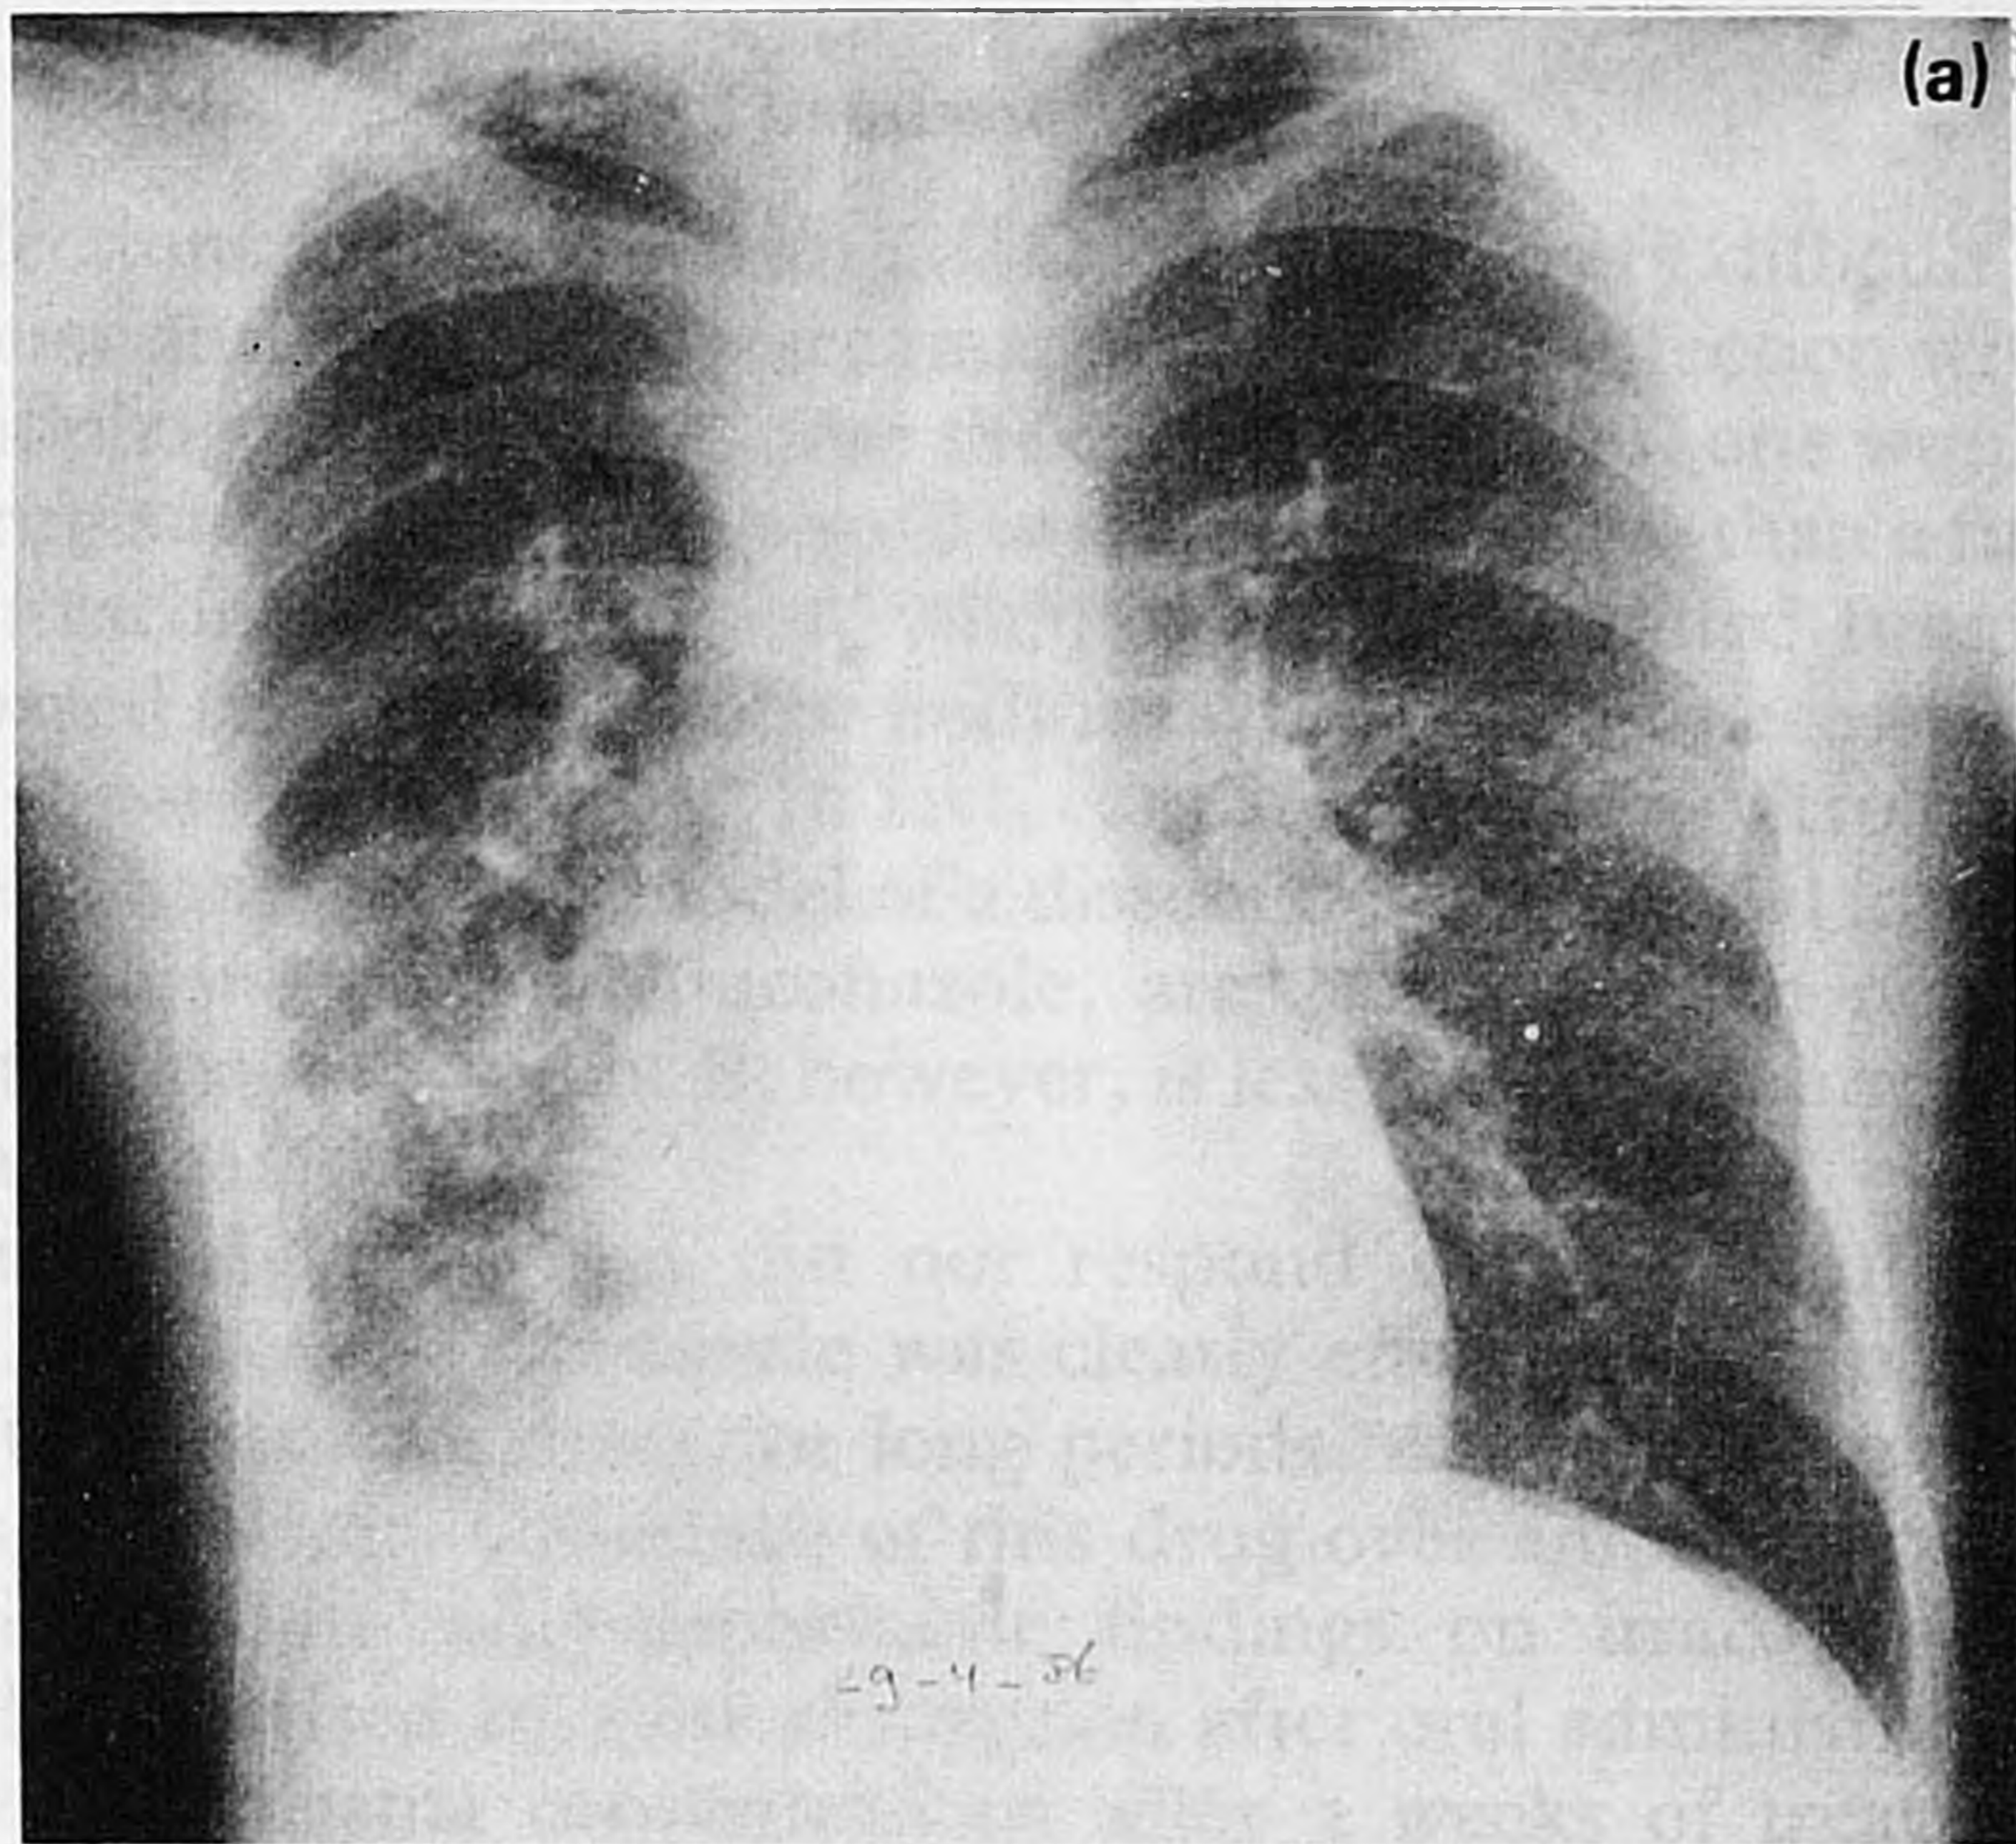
Chest X-rays of a patient with CGD and aspergillosis at the start of treatment with itraconazole (a) and 4 months later (b).
